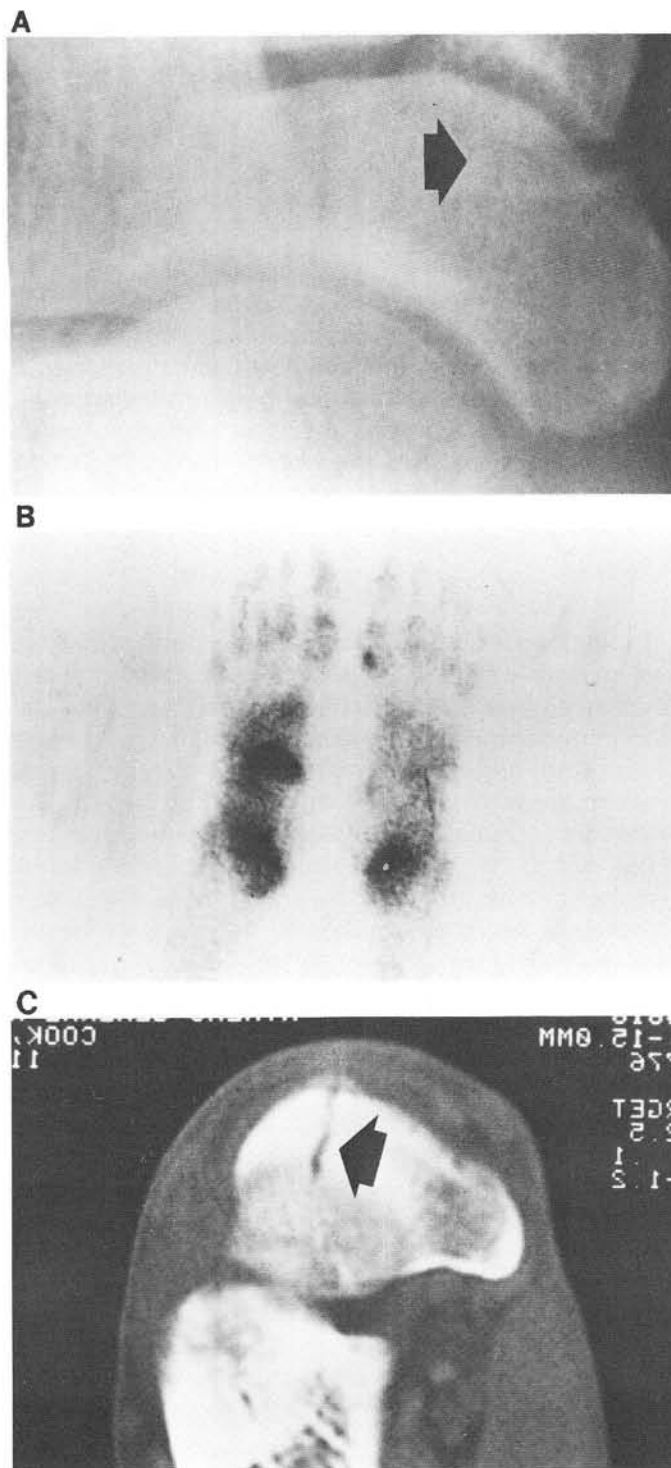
Navicular stress fracture. A. Note questionable cortical break on medial navicular surface. B. Technetium-99m MDP bone scintigraphy demonstrating increased uptake in the region of the left navicular. C. Computed tomography (CT) provides further detail and identifies specific location of navicular stress fracture.
